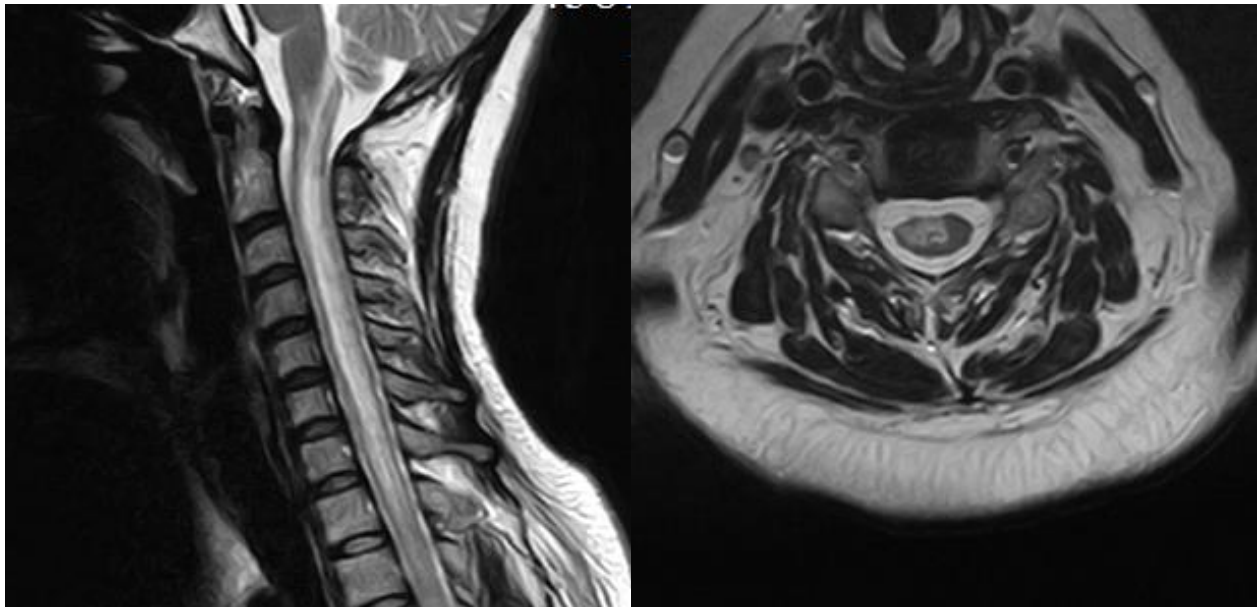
T2-weighted images in the sagittal and frontal planes: in the spinal cord at the level of all cervical and visualized thoracic vertebrae, a focus of pathological signal enhancement is visualized, an elongated shape, 76x8x4 mm in size. There is slight annular enhancement on post-contrast tomograms.
